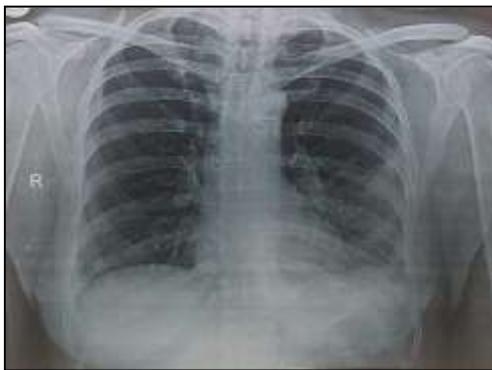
Chest radiograph shows left lower lung zone homogenous opacity (pleural effusion) in previous chest radiograph subsided
